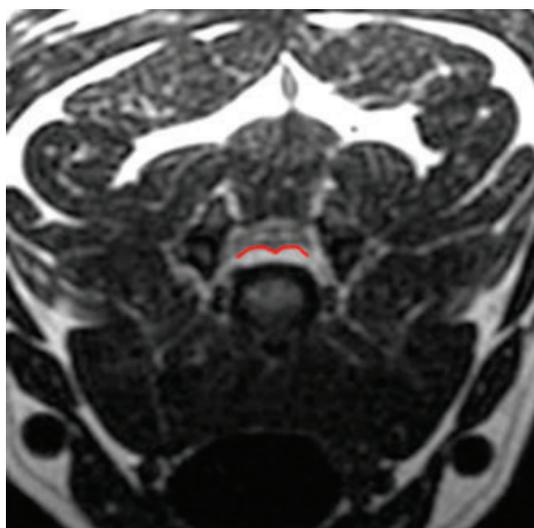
Transverse T2-weighted image of a suspected hydrated nucleus pulposus extrusion. The extruded material lies symmetrically on the midline ventral to the spinal cord. The margin of the extruded material resembles a “seagull”
